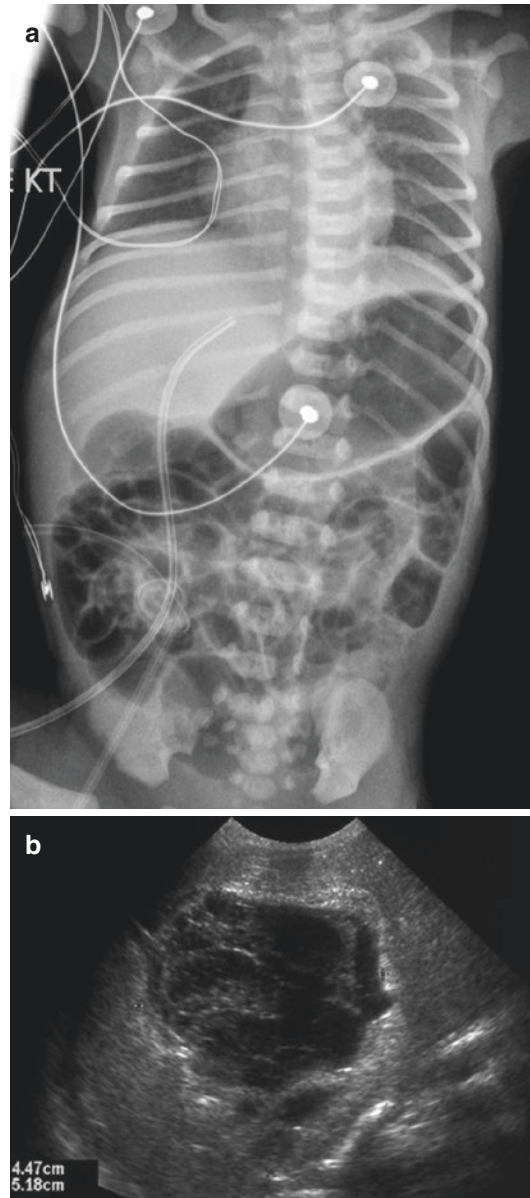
Hematoma due to a misplaced UC—(a) Plain film of the abdomen at birth. The tip of the UC lies within the liver. (b) US of the liver at 10 days—Oblique view through the liver showing a large hypoechoic hematoma. It calcified first and then progressively disappeared on long-term follow-up
